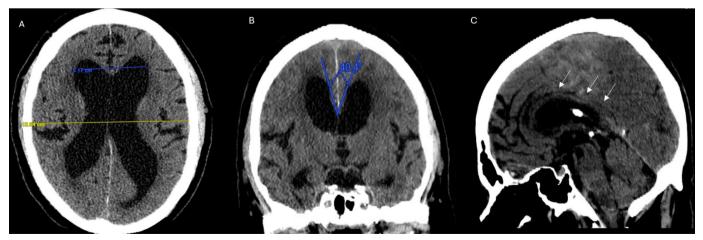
Demonstration of radiographic features of NPH. (A) Axial CT head demonstrating Evans index of 0.44; (B) Coronal CT head demonstrating acute callosal angle of 40.4° with DESH; (C) Sagittal CT head demonstrating cingulate sulcus sign (white arrows). DESH, disproportionately enlarged subarachnoid space hydrocephalus; NPH, normal pressure hydrocephalus.
